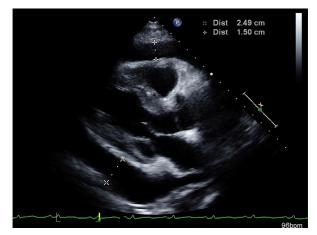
Echocardiography shows a large pericardial effusion with signs of impending cardiac tamponade.
